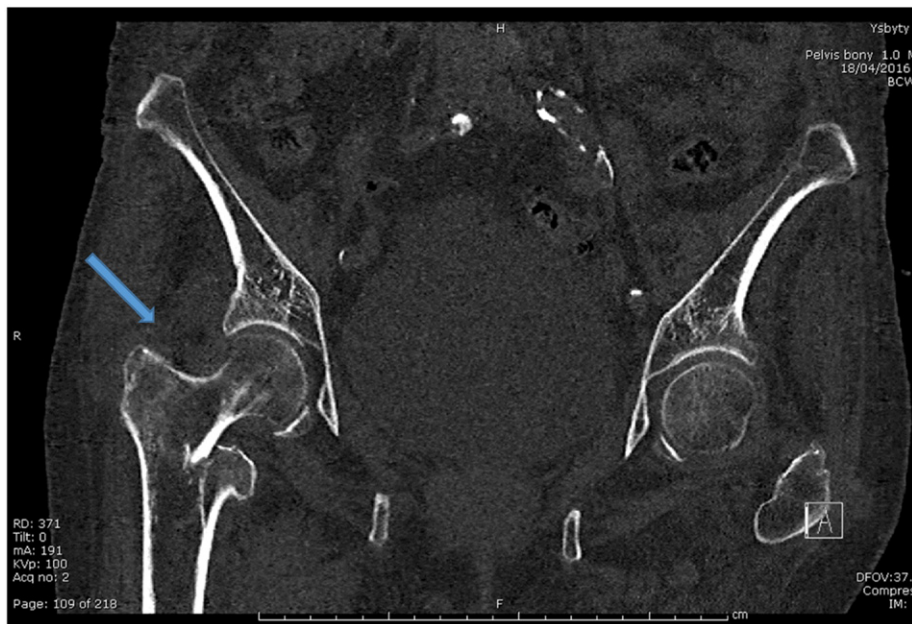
CT scan images showing intracapsular and extracapsular fracture neck of femur.
